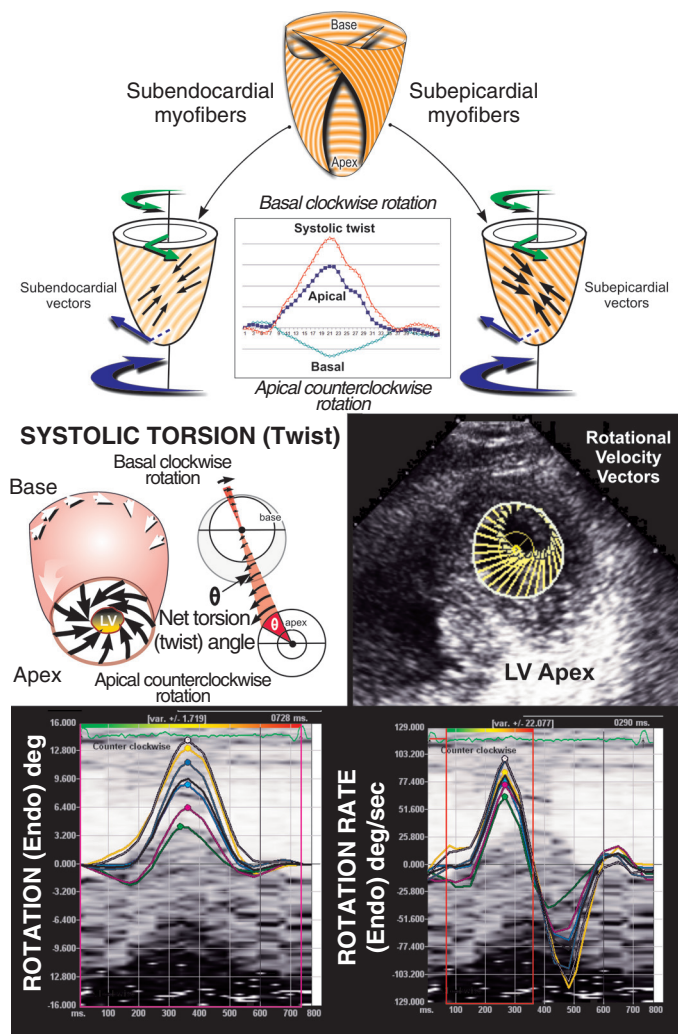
Ventricular torsion (or twist) can be assessed by comparing the rotation occurring at the base of the heart with that occurring at the apex. Rotation at two locations can be assessed by speckle tracking echocardiography. Rotation and the rate of rotation can be assessed and displayed. (Modified from Bulwer BE, Solomon SD: Assessment of systolic function. In Solomon SD [ed]: *Atlas of Echocardiography*. 2nd ed. Philadelphia, Current Science/Springer Science, 2009, p 63.)
